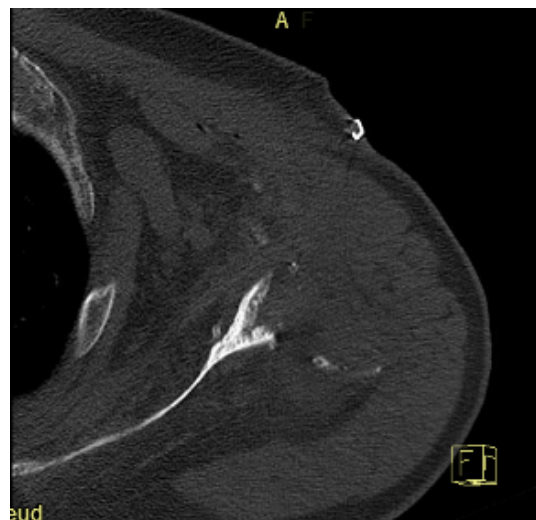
Axial CT showing glenoid loss after explantation.
